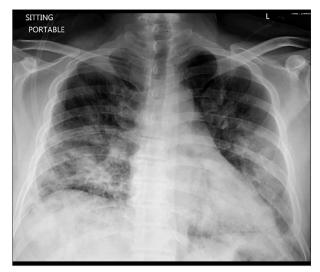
Chest x-ray during the initial admission shows bilateral infiltrate mainly prominent in lower lobes at time of initial presentation.
